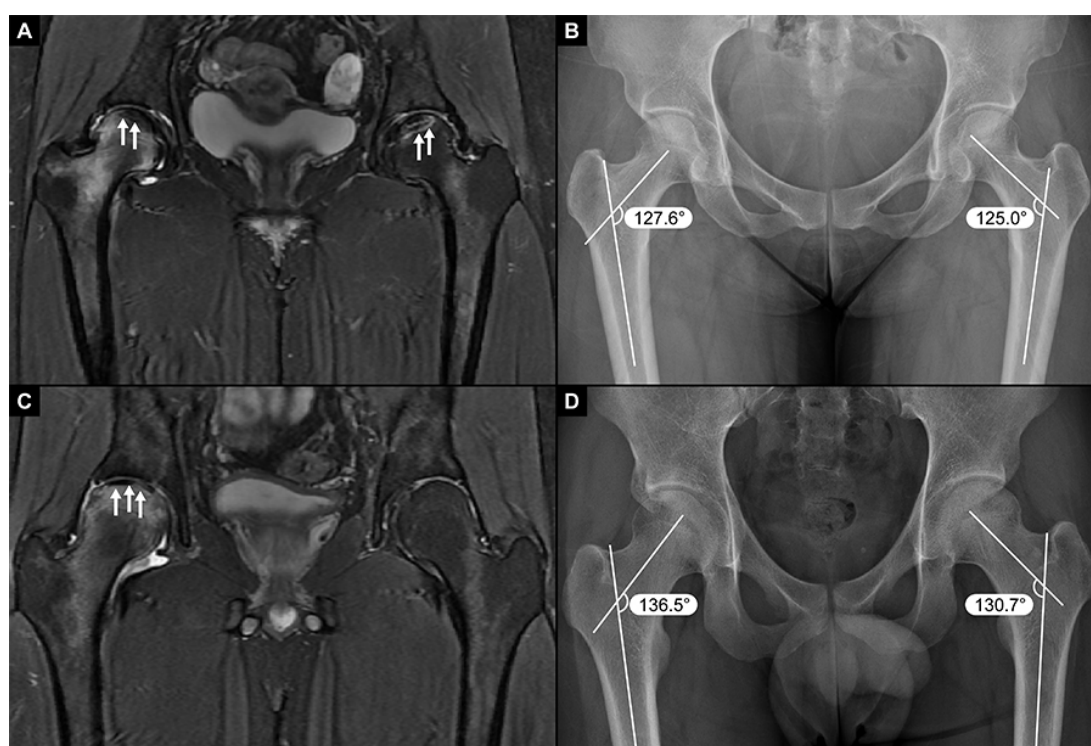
Representative cases of femoral head Stress Fracture (SF) and Avascular Necrosis (AVN). In a 32-year-old woman diagnosed with bilateral femoral head AVNs, (A) hip MRI showed bone marrow edema with concave bands/lines (arrows) on the articular surface at bilateral femoral heads and (B) hip Anteroposterior (AP) radiograph showed normal Femoral Neck Shaft Angle (FNSA) at bilateral femurs. In a 31-year-old man diagnosed with right femoral head SF, (C) hip MRI showed bone marrow edema with convex fracture line (arrows) at right femoral head and (D) hip AP radiograph showed coxa valga at right femur (FNSA, right = 136.5° , left = 130.7°).
